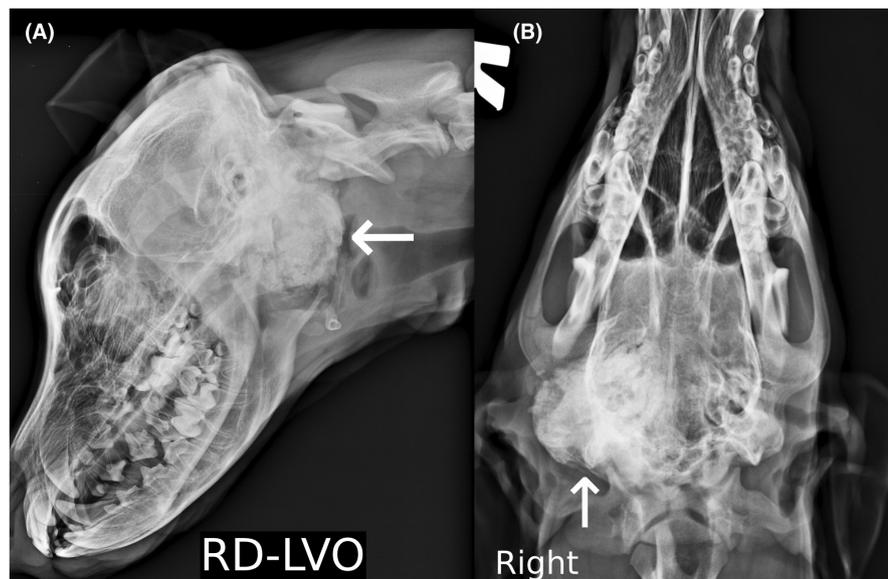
DV (A) and oblique (B) radiographs of the skull, showing the rounded mass (white arrows) of mineral opacity, located at the region of the right tympanic bulla.
